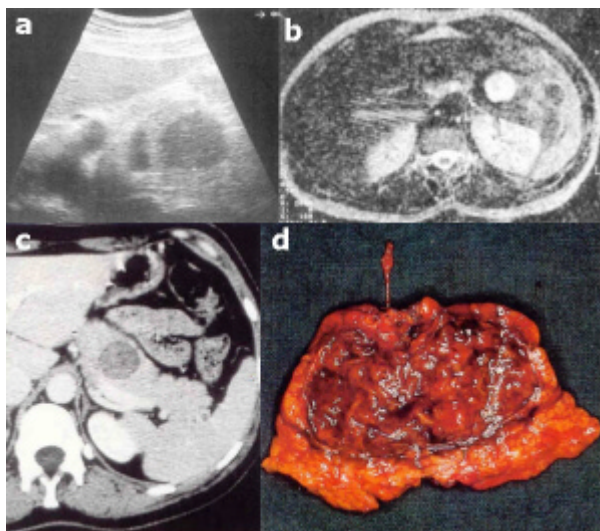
Case 3. US showing a round, well-defined, non-homogeneous mass of the pancreatic body, 3x3 cm in diameter (a.). Magnetic resonance (b.) and a computed tomography scan (c.) confirmed the ultrasound findings. A conservative, radical pancreatic resection was performed with a central pancreatectomy including the neoplasm (d.). (Image d. is presented in another contribution by the same authors, published in these Proceedings [30], in order to describe aspects not related to those reported here)
